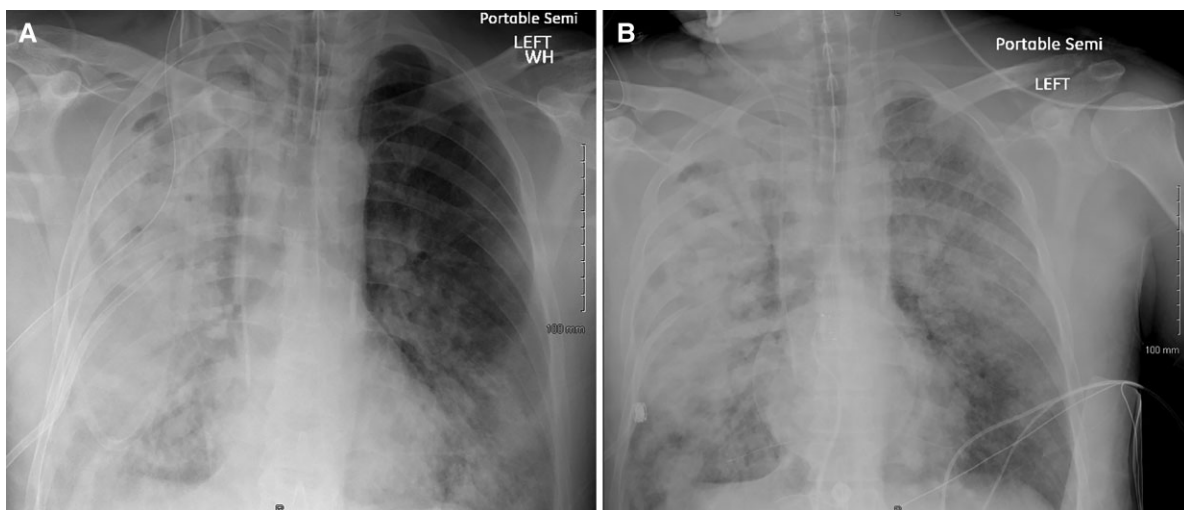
A, Portable chest radiograph for case patient 1 from the afternoon of hospital day 6, before antitoxin dose 1, showing extensive air-space consolidation throughout most of the right lung and nodular infiltrates throughout the left lung. B, Portable chest radiograph for case patient 1 from early morning hospital day 7, shortly after antitoxin dose 1, showing extensive confluent infiltrates throughout both lungs, with greater confluent disease of the right lung.
